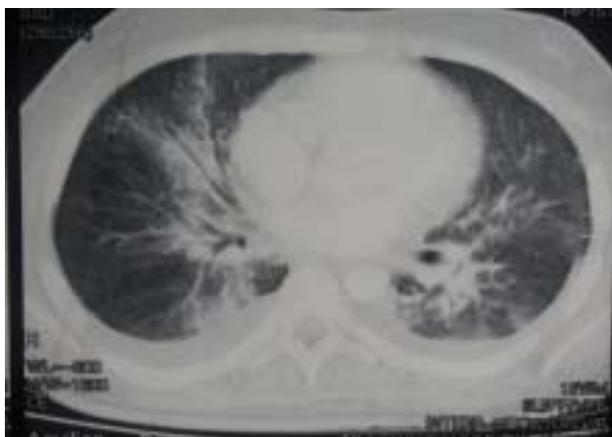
CT scan of the chest showed pulmonary infiltrates, hilar lymphadenopathy and pleural effusion.
